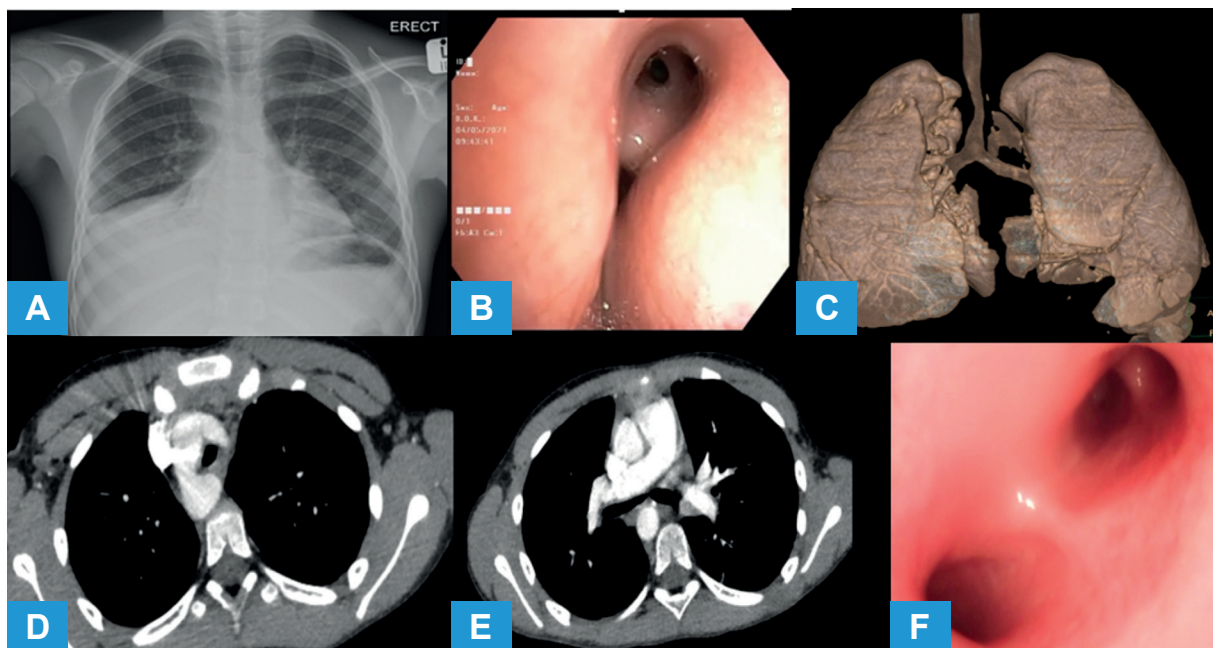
8-year-old boy, who had previous surgery for double aortic arch presented with: (A) collapse of the RML and RLL on the chest X-ray; (B) bronchoscopy image demonstrates compression of the opening of the RMB; (C, D, E) chest CT scans confirms large right-side arch causing distal trachea and RMB compression. The descending aorta (E) running on the right side also causes compression of the right main bronchus; (F) bronchoscopy image during posterior aortopexy showing that the compression has significantly improved.
